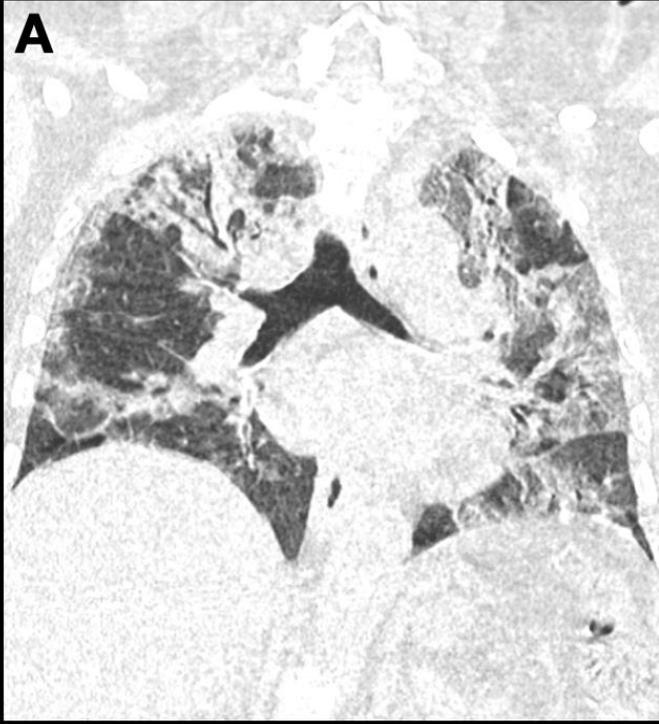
HRCT image of the chest in a patient with severe fibrotic lung lesions 4 months after hospitalization for COVID-19 compared with that during acute COVID-19.
